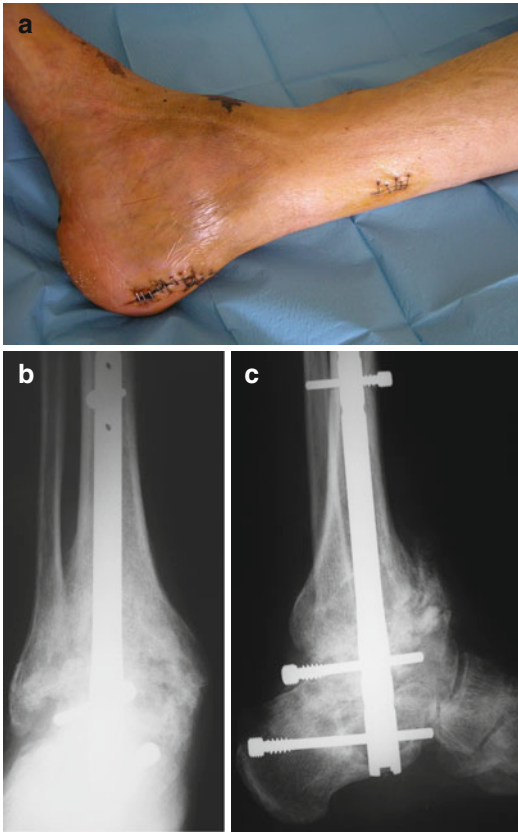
Right ankle arthrodesis with a retrograde locking nail in a patient with severe hemophilic arthropathy of the tibiotalar and subtalar joints: lateral postoperative view of the ankle (a). Anteroposterior radiograph after arthrodesis (b). Lateral view after ankle fusion (c)
